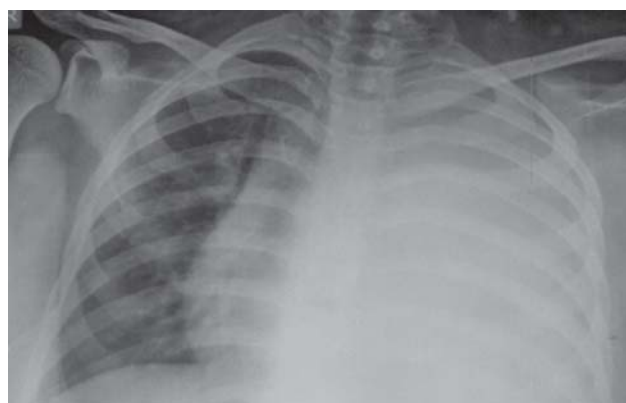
Chest radiograph (antero-posterior view) showing massive left-sided pleural effusion with a mediastinal shift.
